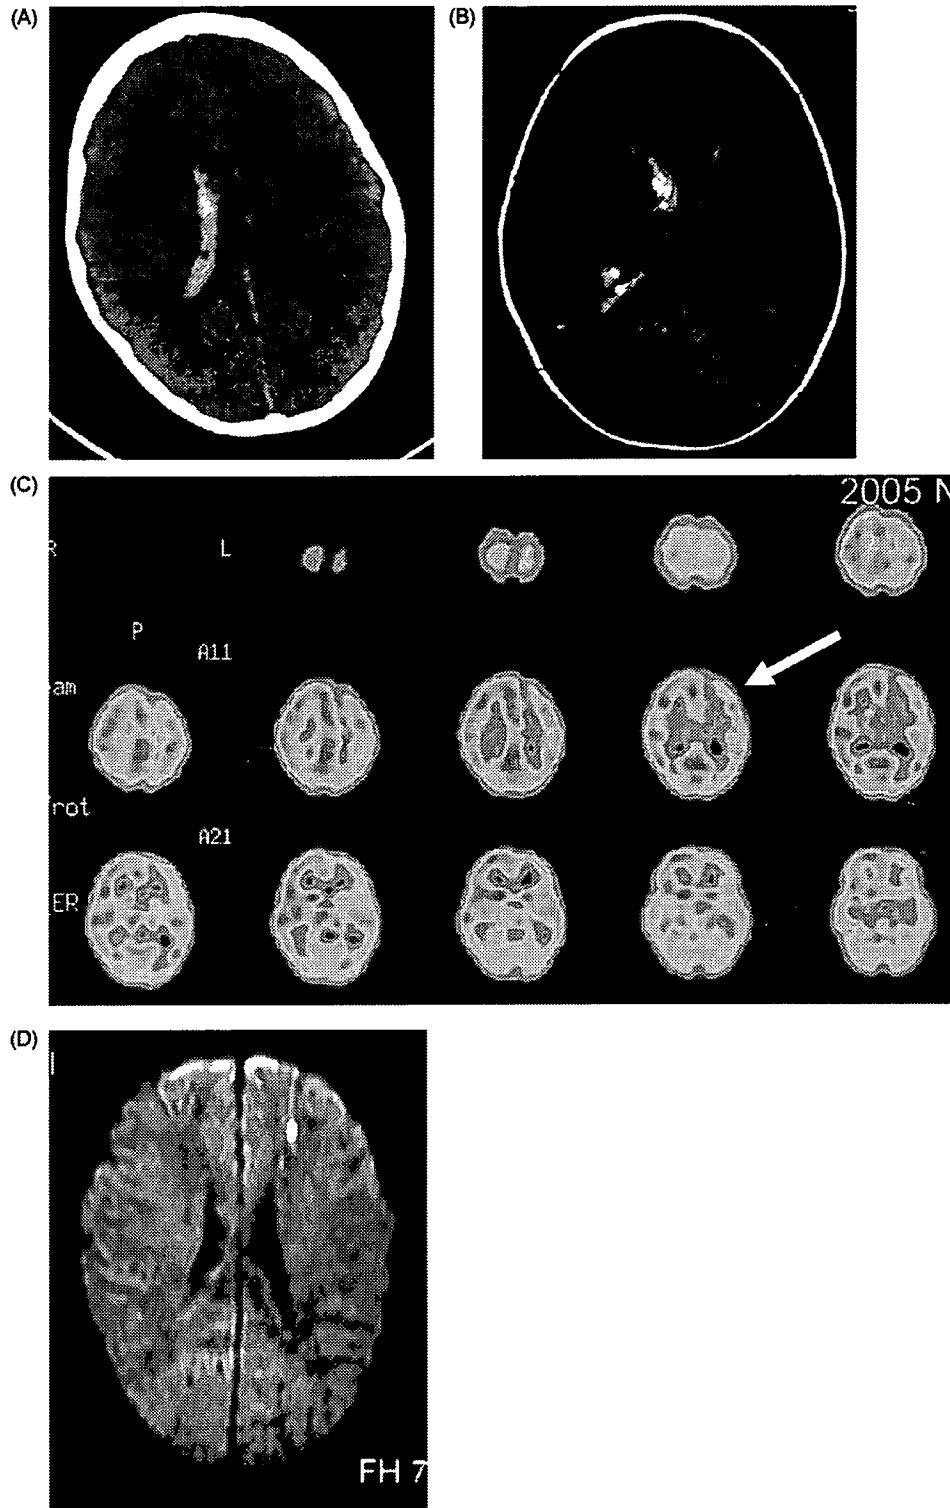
(A) A computed tomographic scan revealed a tiny intracerebral hemorrhage in the right paraventricular white matter and clots in the right lateral ventricle. (B) FLAIR magnetic resonance images did not show any other hemorrhagic or ischemic lesions. (C) SPECT using ^{123}I -IMP showed a modest, and significant, reduction of the regional CBF in the left frontoparietal cortex (arrow). (D) Magnetic resonance imaging showed restricted diffusion in the left frontal subcortex on the diffusion-weighted image.
